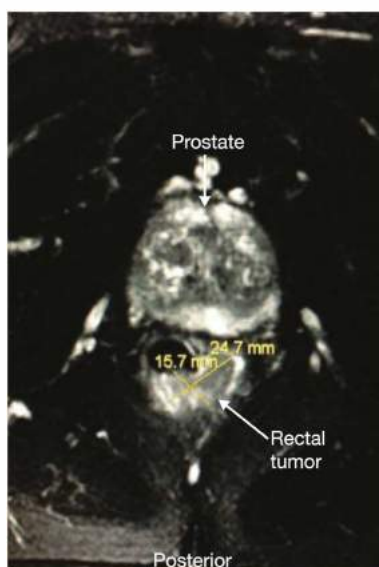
• Rectal-protocol MRI showing a rectal tumor involving the posterior and lateral rectal walls. There is a clear plane of separation from the prostate anteriorly, ruling out a T4 lesion.
